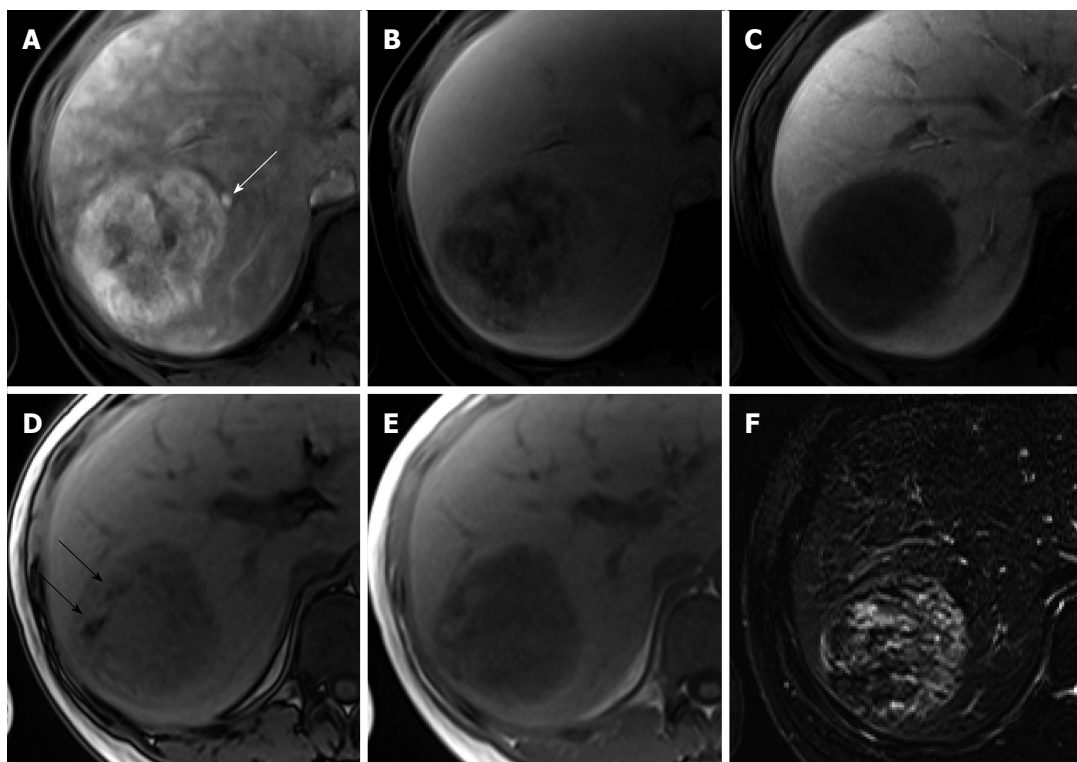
Angiomyolipoma in a 33-year-old woman. A: Hepatic arterial phase using gadoteric acid shows heterogeneous arterial enhancement of the tumor. Early venous drainage to the right hepatic vein is seen (white arrow); B: Transitional phase shows heterogeneously low signal intensity; C: Hepatobiliary phase shows homogeneously low signal intensity; D, E: Opposed phase (D) and in-phase (E) T1-weighted gradient echo images reveal hypointense mass with area of signal drop on opposed-phase image (black arrows), indicating fat-containing lesion; F: T2-weighted image shows heterogeneous signal intensity of the tumor.
